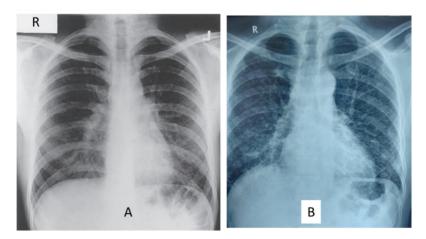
X-ray Chest PA view showing reticular and nodular opacities confined to lower zones (A) and similar opacities involving all the lung zones except apical areas (B).
